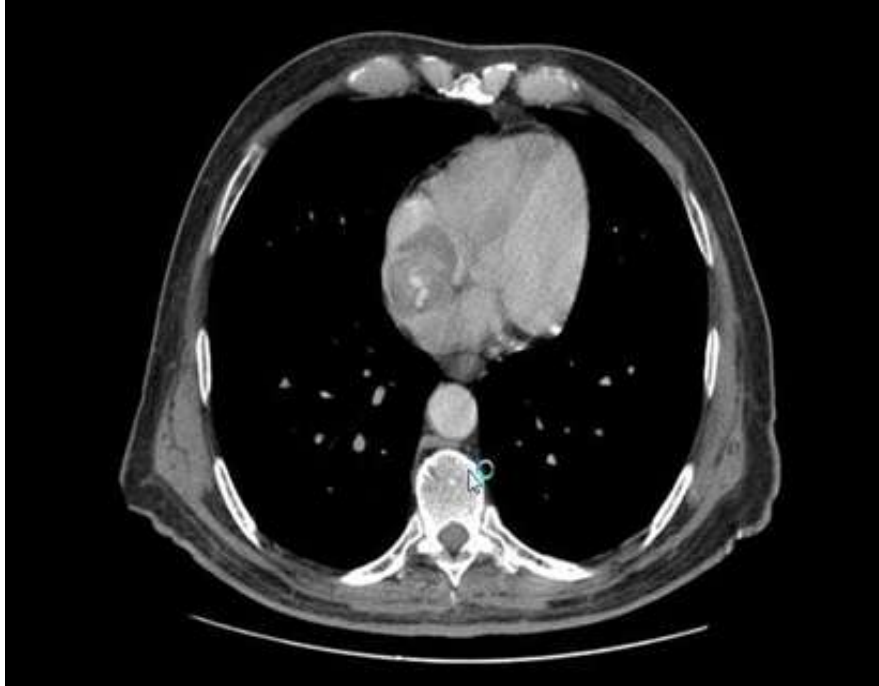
Cardiac CT oblique five-chamber view in transverse section with horizontal long axis on Iode contrast demonstrating a large right atrial mass.
